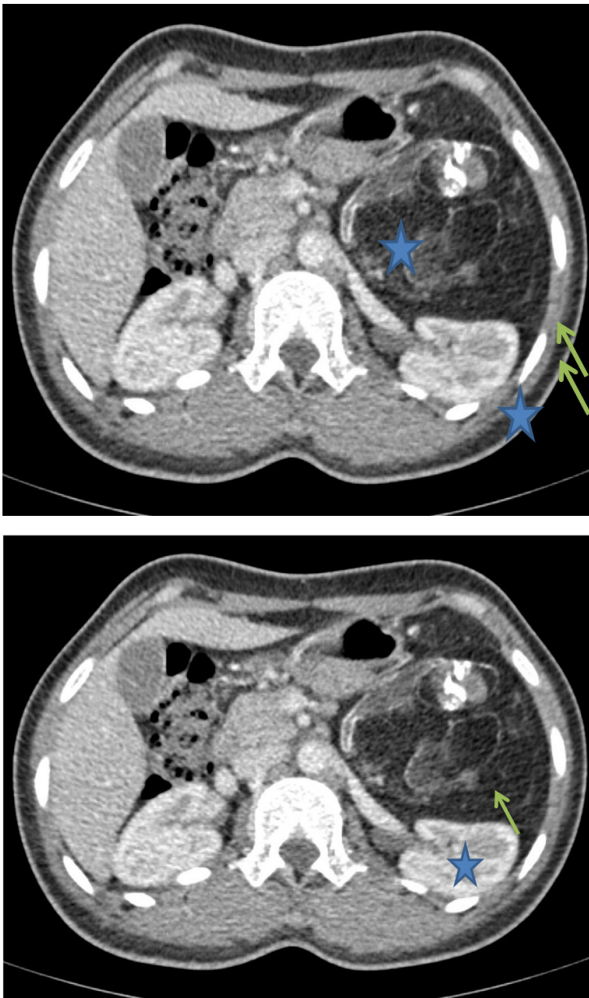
Axial CT scan of the upper abdominal level with contrast injection in venous phase showing the retroperitoneal location of the previously described mass with a slight mass effect on the left kidney (asterisk).
